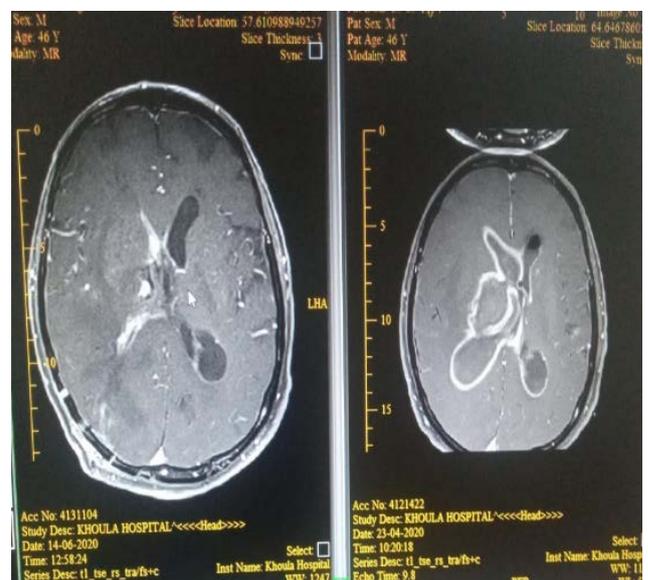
Pre and post operative MRI brain after endoscopic evacuation of the abscess
